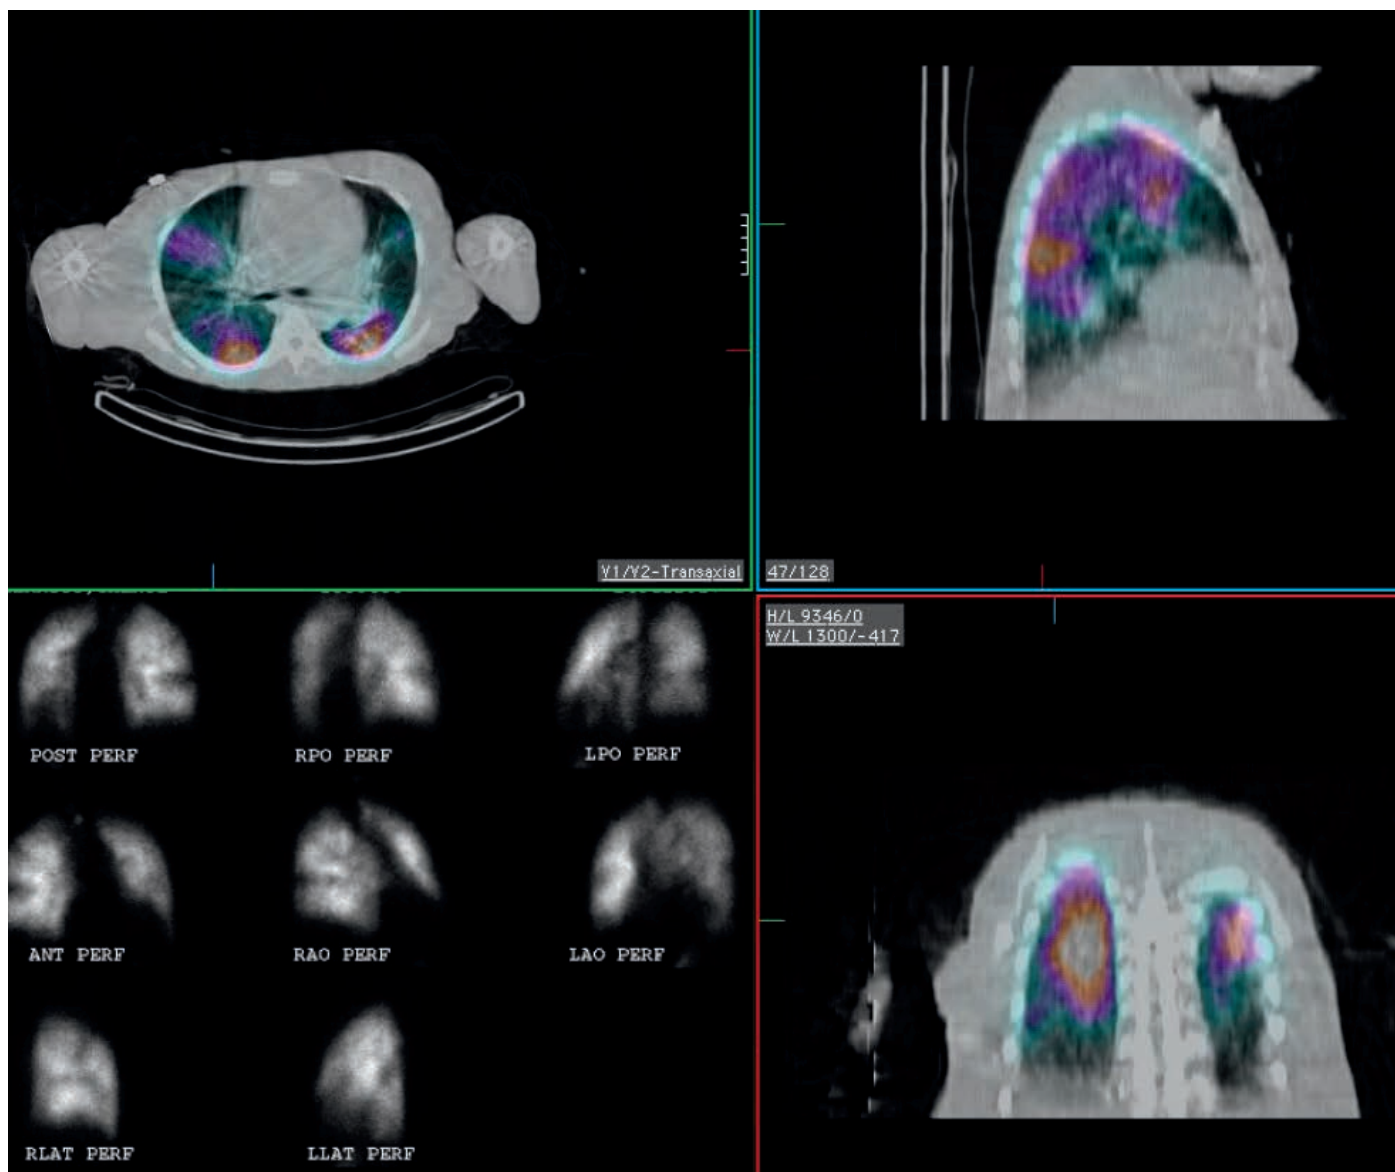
Single photon emission computed tomography (SPECT) and Q scan demonstrating heterogeneous perfusion in chronic thromboembolic pulmonary hypertension.
